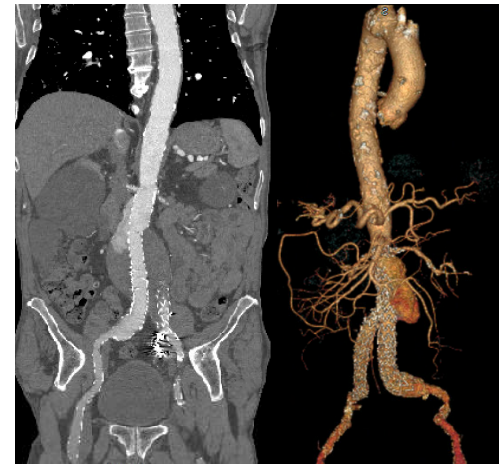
CTA showing type 1a endoleak.
